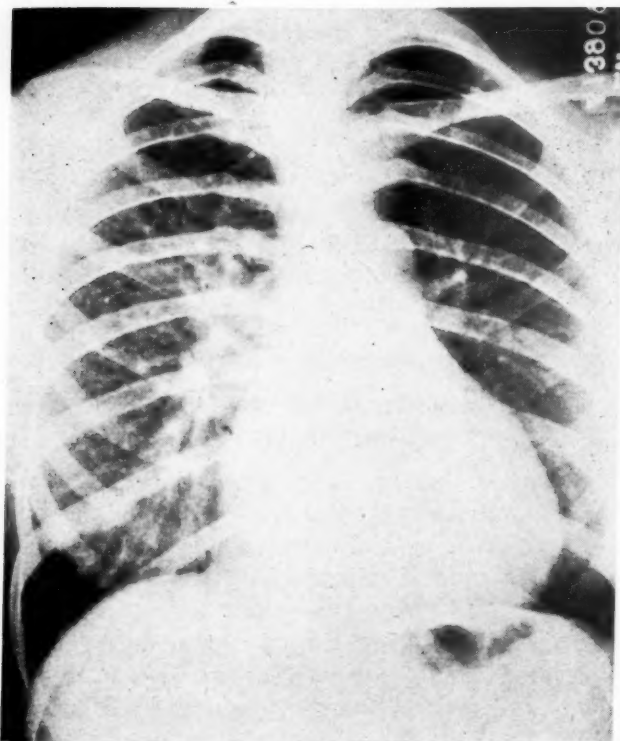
X-ray of the chest before surgical ligation (May 23, 1944).
